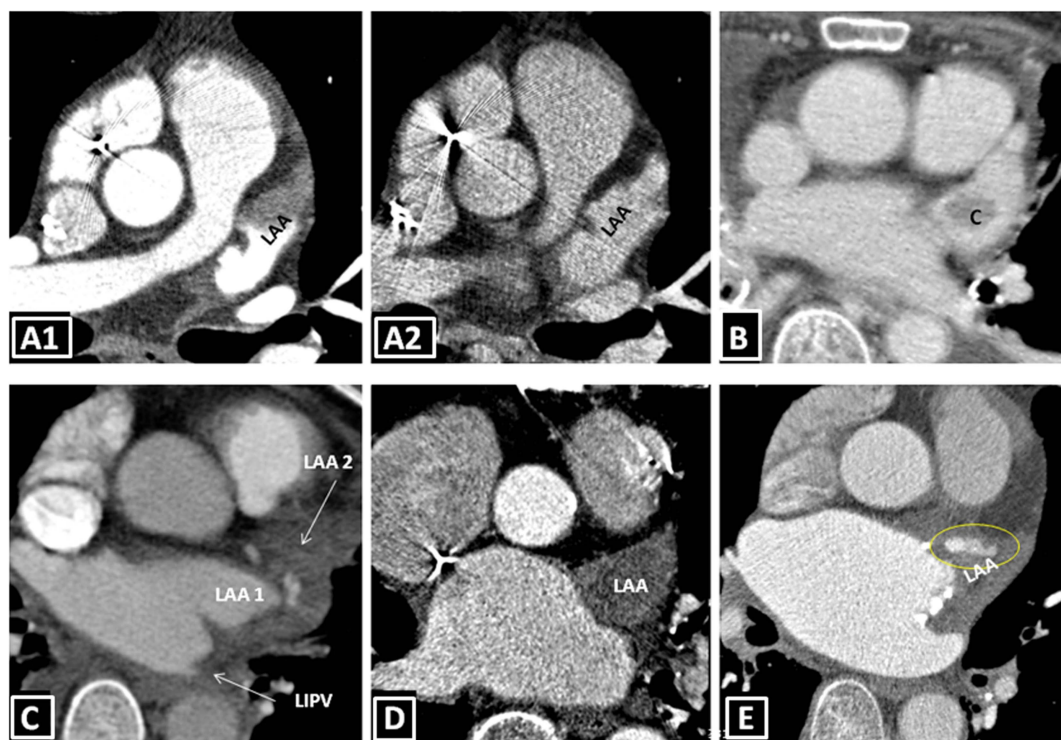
CT findings in patients with atrial fibrillation in relation to the left atrial appendage (LAA). (A1, A2) Axial CT image at first pass of contrast showing filling defect in the LAA which disappears on the delayed phase (A2) consistent with pseudothrombus. This phenomenon is very common in patients with atrial fibrillation at the time of scan. (B) Delayed post-contrast axial CT showing a real thrombus (c) in the LAA lumen. (C) Axial CT same day after Maze ablation showing partial exclusion of the LAA (LAA2). Residual patent LAA (LAA1) and occluded left inferior pulmonary vein (LIPV) are evident. (D) LAA appearance after successful percutaneous exclusion. (E) Incomplete LAA occlusion after ablation showing contrast extravasation into the ablated part (circle).
